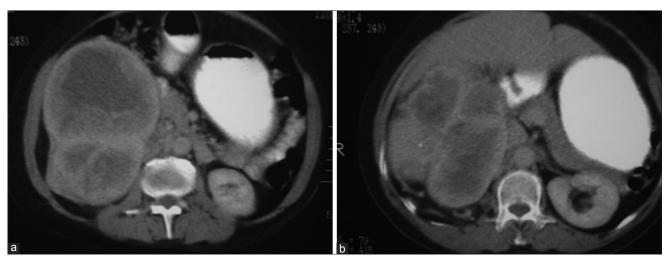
(a and b): CT scan showed a well-delineated mass arising from upper pole of right kidney measuring 10 x 10 cm with contrast enhancement
